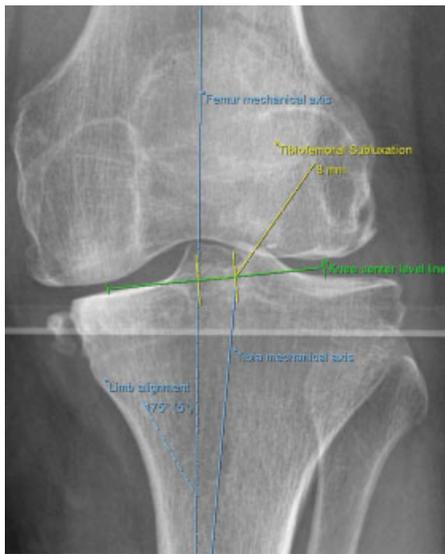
Radiograph demonstrating tibiofemoral subluxation and the method for measurement.
